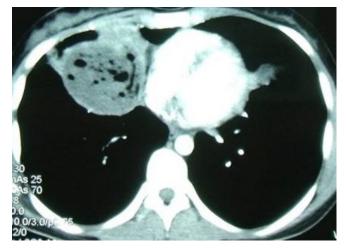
Thorax CT showing hydatid cyst as an abscess.
